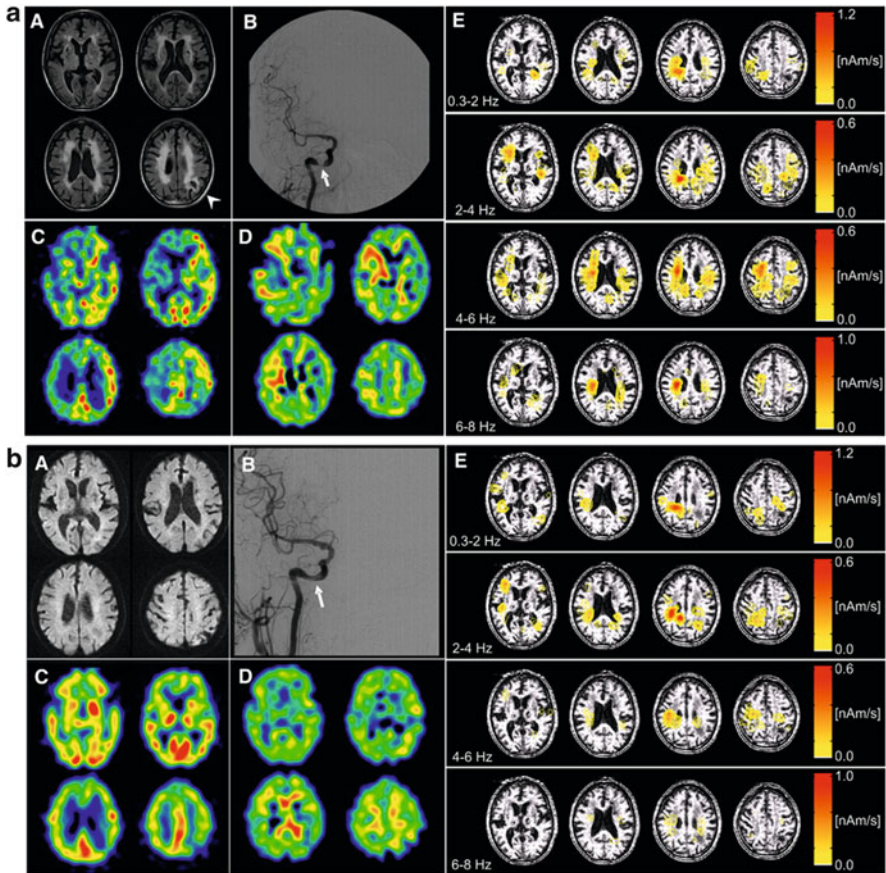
(a) A 70-year-old man with the severe stenosis of right internal carotid artery showed slow wave activity in preoperative state by sLORETA of MEG. (A) MRI (FLAIR) showed no severe cerebral infarction, excluding old infarct lesion in the left parietooccipital area (*arrowhead*) and multiple lacunar infarctions in bilateral basal ganglia and periventricular white matter. (B) Cerebral angiography showed N90 % stenosis of the C5 segment of the right internal carotid artery (*arrow*). (C, D) 15O-gas PET showed reduced CBF (C, 32.5 ml/100 g/min) and increased OEF (D, 73.3 %) in the right cerebral cortex. (E) Quantitative imaging of cerebral neuromagnetic fields using sLORETA-qm in four frequency bands showed distribution and increased intensities of slow waves dominantly in the parietooccipital area of the right cerebral hemisphere. Distribution of slow waves was also recognized in the left parietooccipital area and periventricular white matter corresponding with old infarct lesion (Sakamoto et al. [19]). (b) Postoperative investigations in same case. (A) MRI (DWI) showed no additional infarction in any area of cerebrum. (B) Cerebral angiography showed recovery of stenosis after CAS of the right internal carotid artery (*arrow*). (C, D) 15O-gas PET showed increased CBF (C, 38.0 ml/100 g/min) and decreased OEF (D, 47.1 %) in the right cerebral cortex. (E) Quantitative imaging of cerebral neuromagnetic fields with sLORETA-qm in each frequency band showed decreased intensities at 2–4 Hz, 4–6 Hz, and 6–8 Hz in the parietooccipital area of the right cerebral hemisphere, although no apparent change of intensity at 0.3–2 Hz was observed compared with preoperative data (Sakamoto et al. [19])
